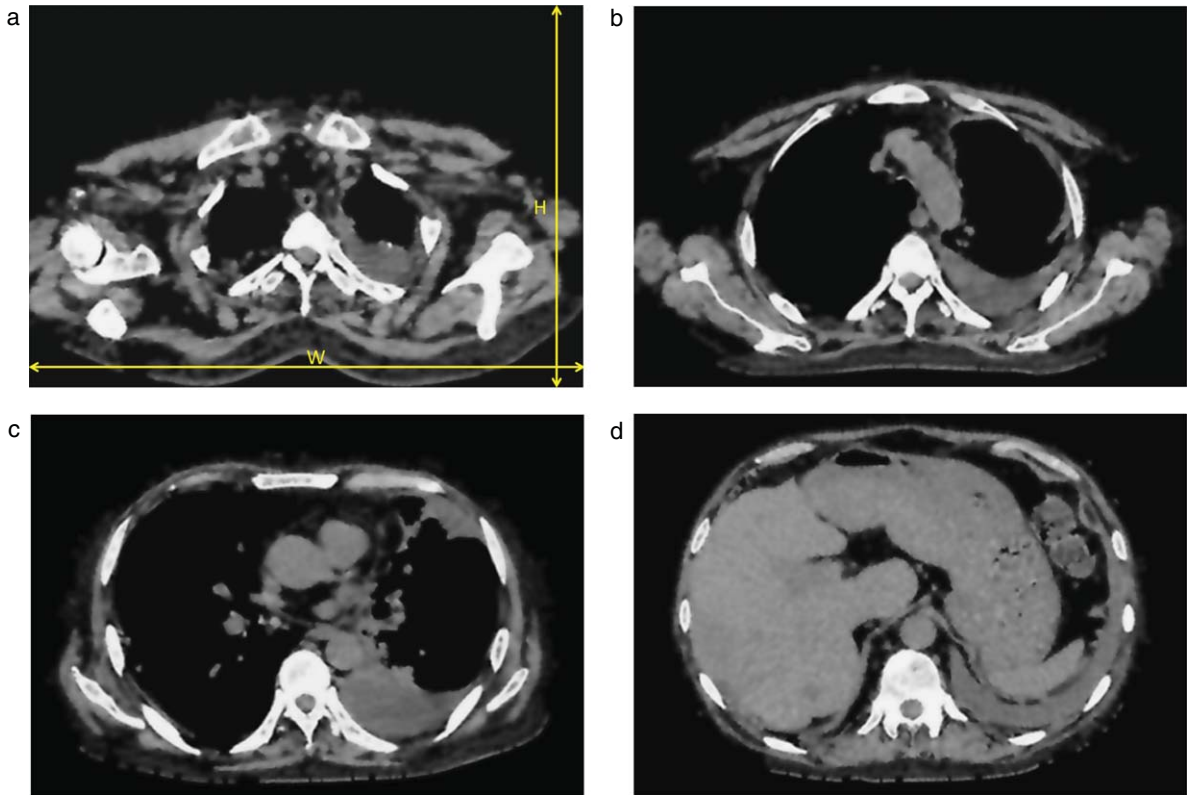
The patient CT scans.
